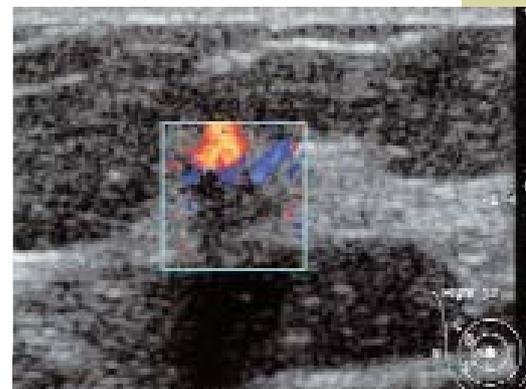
Findings from Fig. 21 in color Doppler: distinct flow signals
